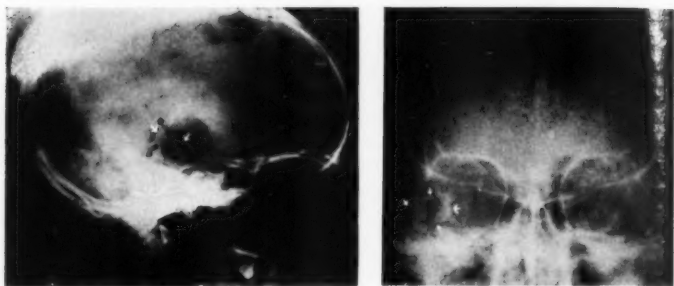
(a). Lateral and anterior radiographs showing a superficial right mid-temporal abscess complicating right otitis media, at the beginning of treatment. The patient was drowsy and confused, with a left homonymous hemianopia, weakness of the jaw muscles on the right and of the facial muscles on the left, and with a flaccid left hemiparesis most marked in the hand and forearm. During treatment he had several episodes of focal motor *status epilepticus*, involving the muscles of the left lower face and left upper limb. Weakness of the left leg recovered first, then the left arm. The left facial paresis and homonymous hemianopia were still present on discharge.
